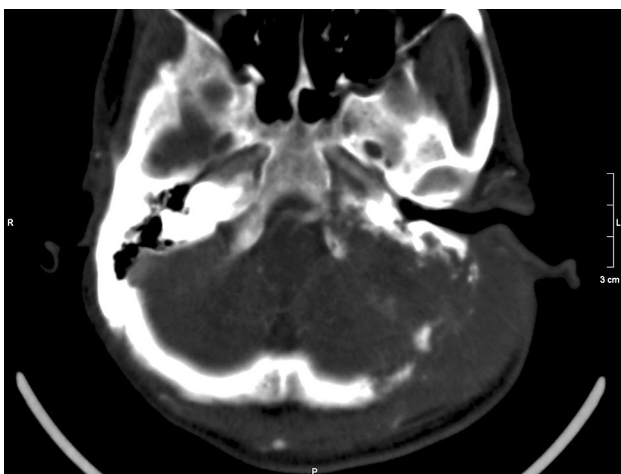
Computed tomography showing the destruction of the great part of occipital and mastoid bone.
